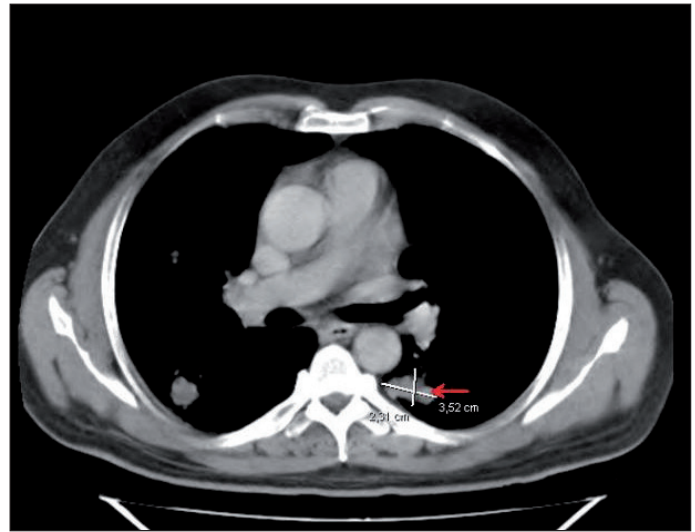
Thorax computed tomography indicating 3.5x2.5 cm sized, bilateral, multiple nodular mass lesions suggesting pulmonary metastasis of RCC.
